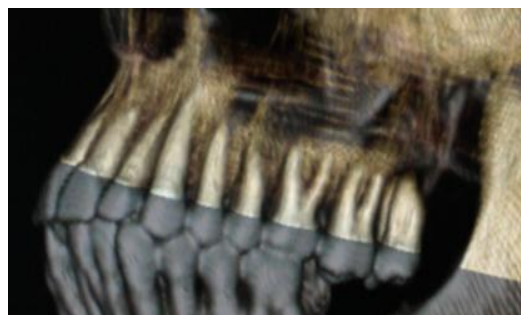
(d) upper left teeth roots of the antemortem mid-face CT with 40% opacity over upper left teeth roots of PMCT.
